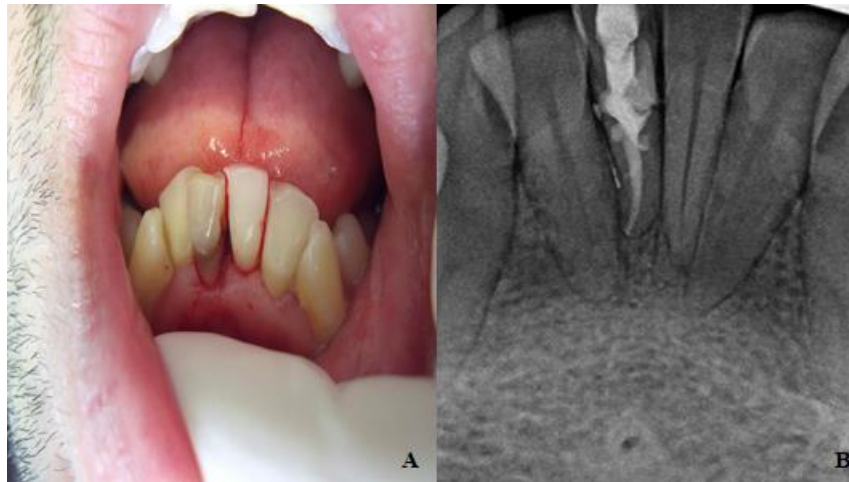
A) clinical image of the intrasulcular flap design B) final radiograph after sealing the perforation.
